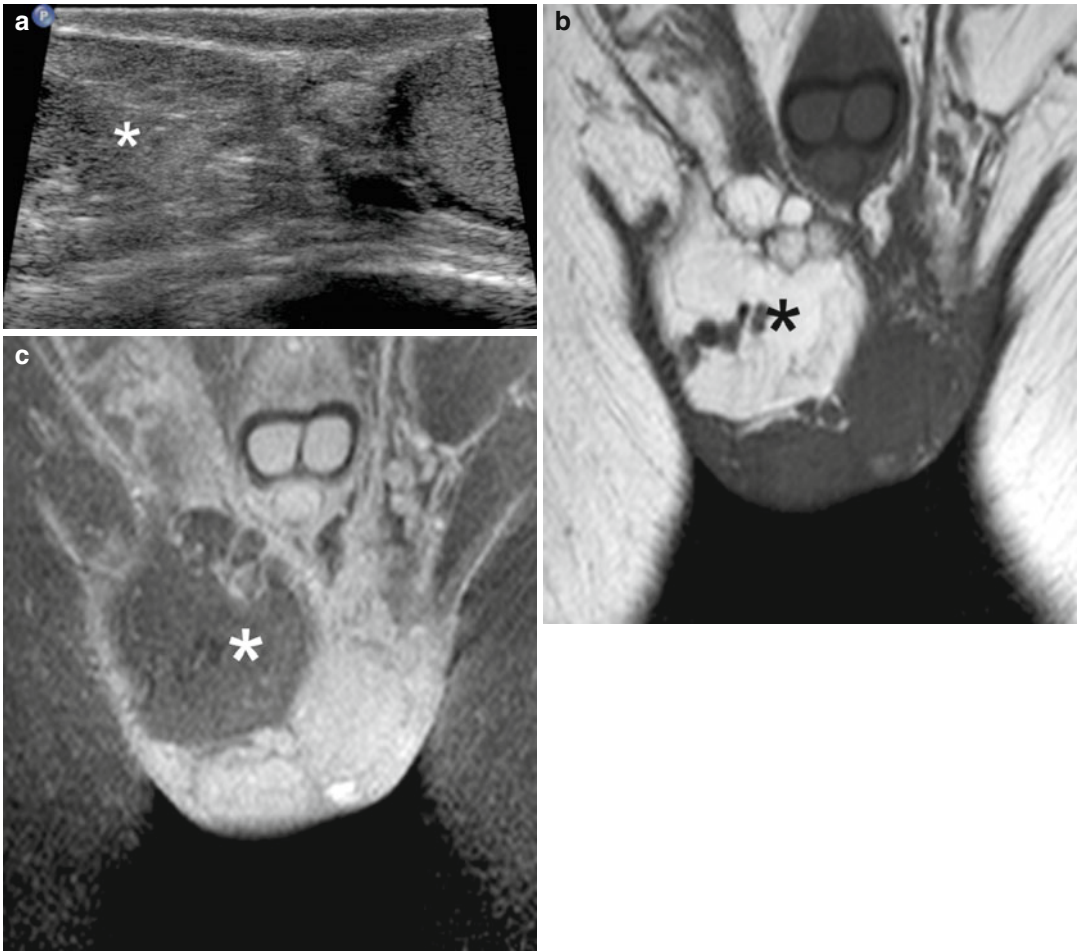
Lipoma of the spermatic cord. (a) Grayscale ultrasonography shows a mass (*asterisk*) with intermediate echogenicity involving the spermatic cord. Due to the limited panoramacity, the relationships of the mass cannot be
